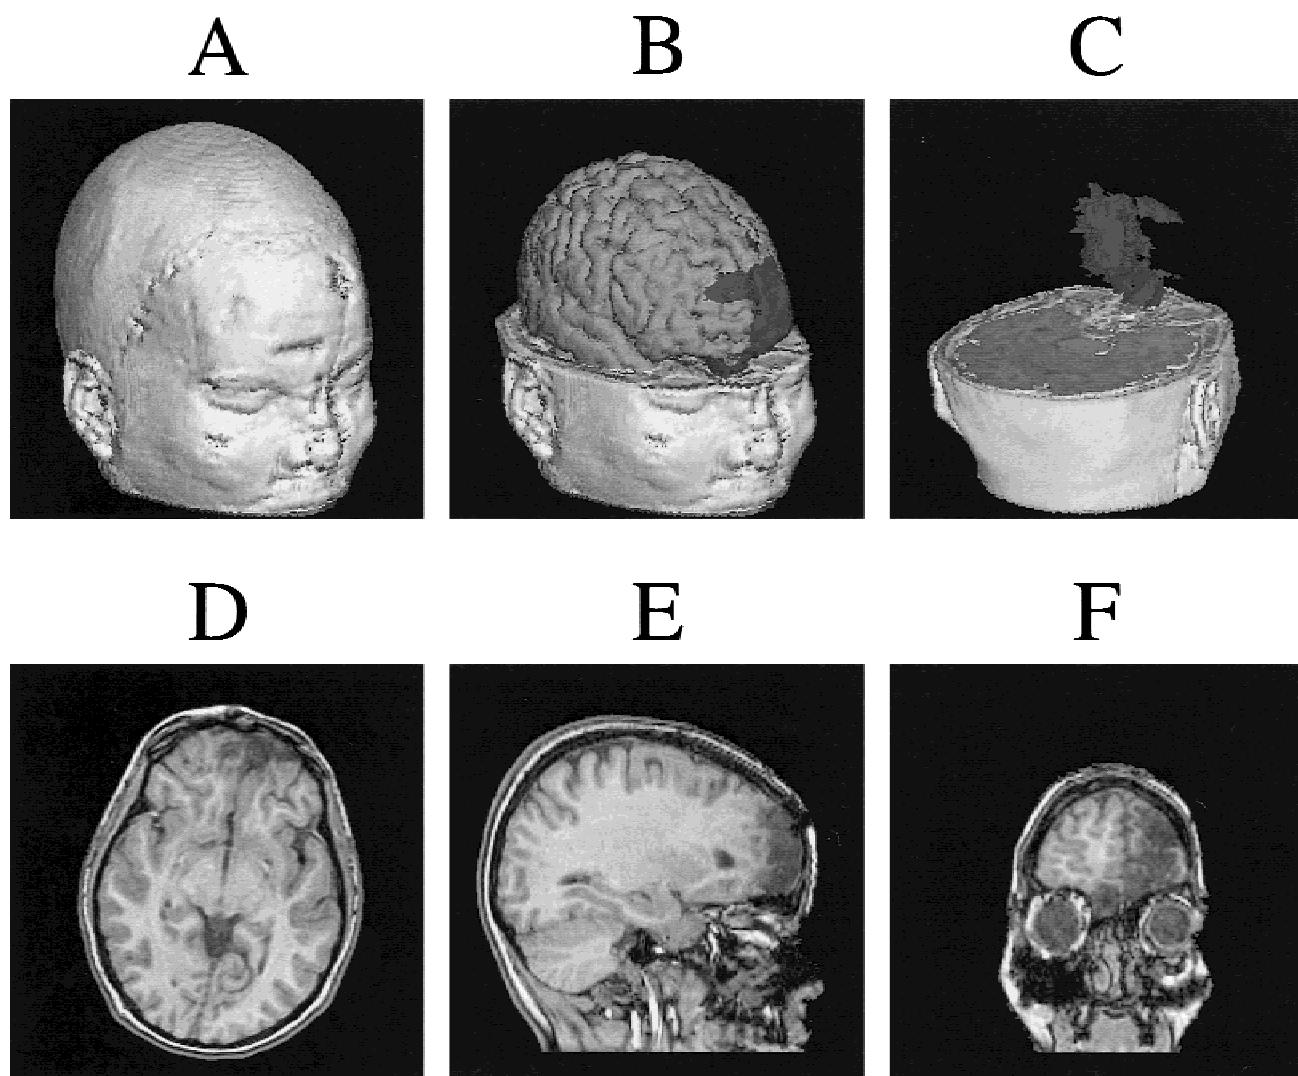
Three-dimensional (3-D) image analysis. A: 3-D depiction of the head based on MR in a child who sustained a serious traumatic brain injury. Note the residual craniotomy scar as well as the soft-tissue and bony defect in the left frontal region. B: By using a combination of thresholding and segmentation techniques, the cortical surface of the brain is isolated from the meninges and cortical bone, and the lesion in the frontal region, particularly in the left frontal area, is isolated. C: The frontal lesion is further isolated from the rest of the brain and can be presented in any 3-D position. D–F: Original axial, sagittal, and coronal MR images depicting the position of the lesion.
